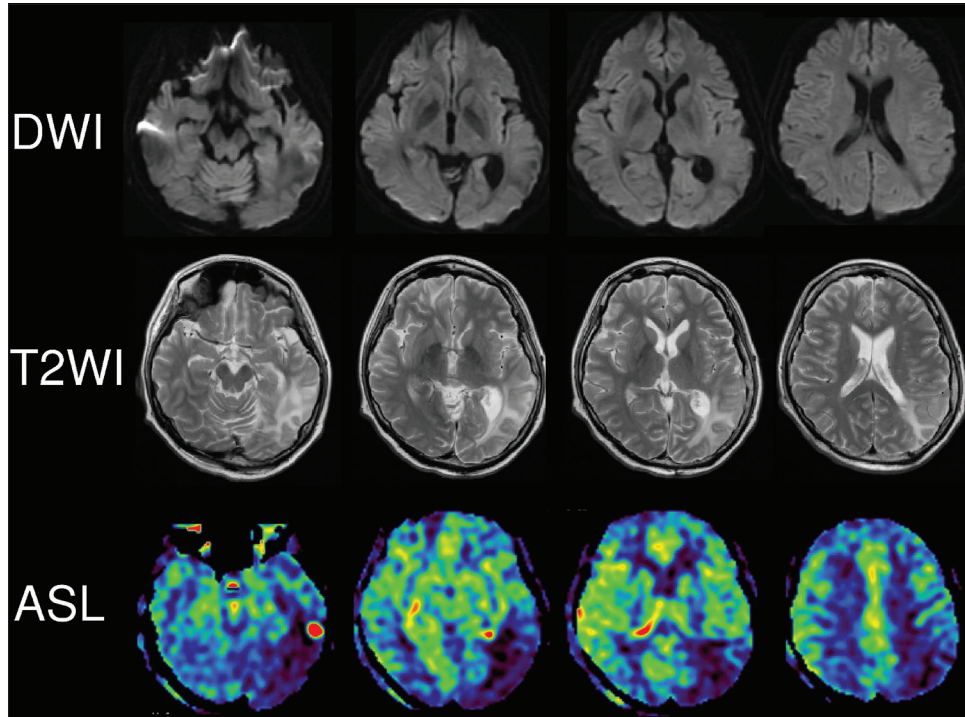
Neuroimaging on day 90. The lesions improved a bit in the diffusion-weighted image and T2-weighted image. Arterial spin labeling image described severely decreased cerebral blood flow in the same region.
